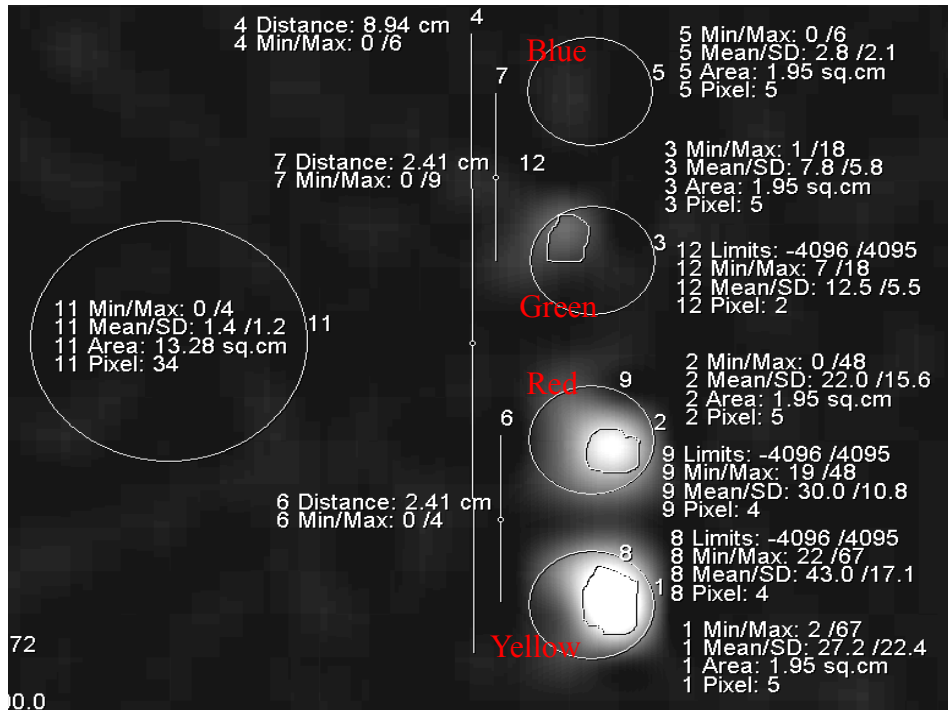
FLASH sequence ^{19}F MRI with TR of 100 ms and matrix size of 64x64.
